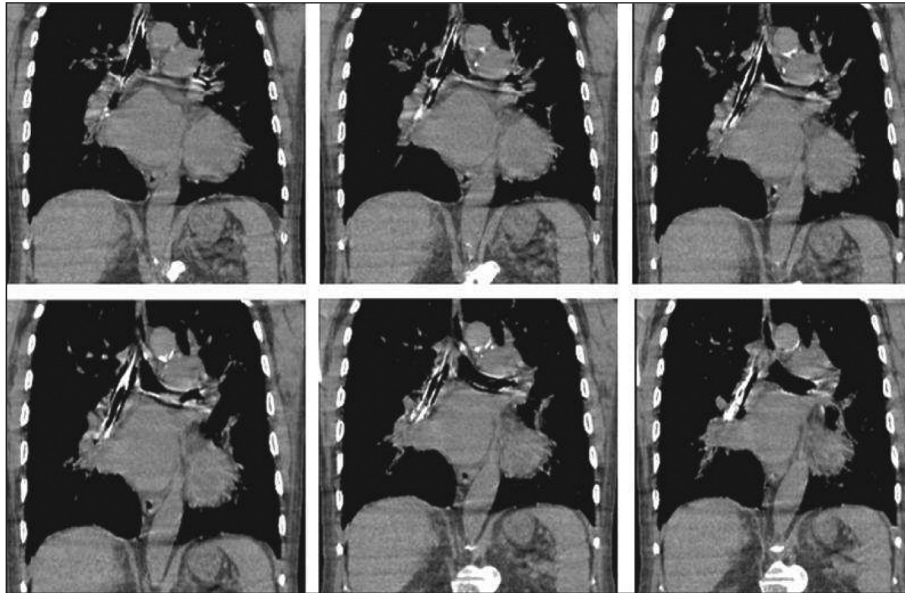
Computed tomography scans show that distal part of broken endotracheal tube was placed from subglottic region to bronchus intermedius.
